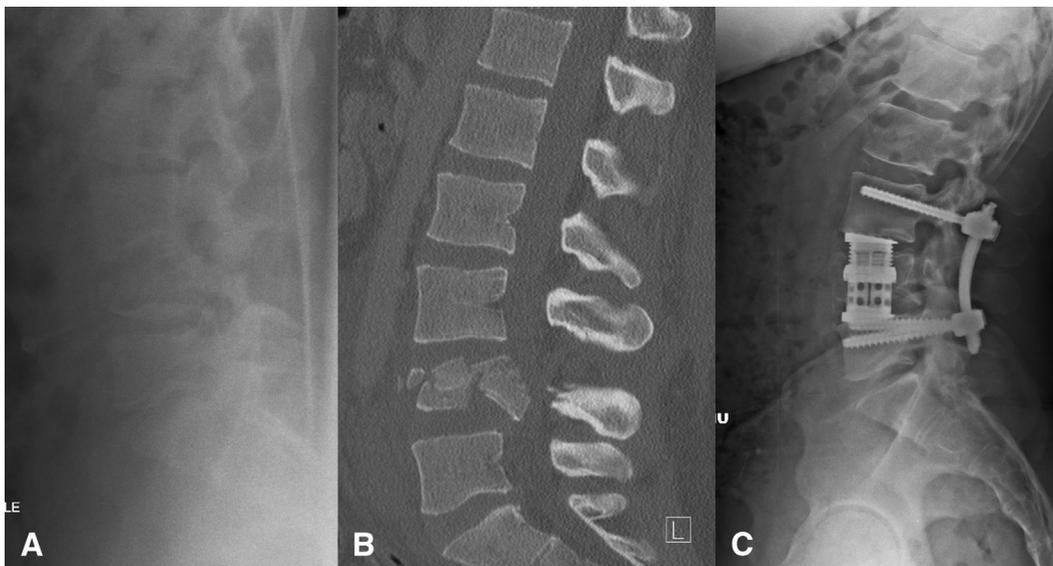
Three sagittal images of the lumbar-spine in a 28-year-old male involved in a motor vehicle crash. (A) Cross-table lateral lumbar-spine radiograph in the emergency department at the time of injury demonstrates a fracture of L4 with loss of vertebral height. (B) Sagittal reconstruction of the lumbar-spine computed tomography demonstrates more detail, including comminution of the fracture, retropulsion of fragments into the spinal canal, and a three-column injury. (C) Six-month follow-up after surgical stabilization and healing, upright lateral lumbar-spine radiograph with maintained alignment and implants.
